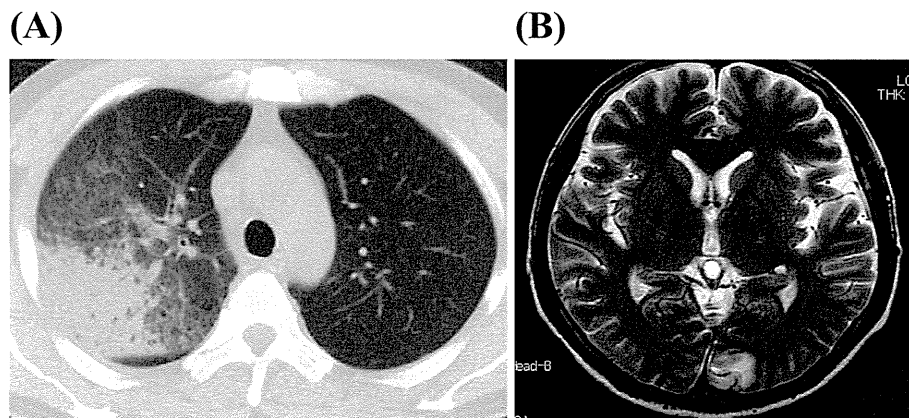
(A) High-resolution chest computed tomography revealed ground-glass opacity around a consolidated area in the right lobe. (B) T2-weighted magnetic resonance imaging demonstrated cerebral infarction in the left occipital lobe.
